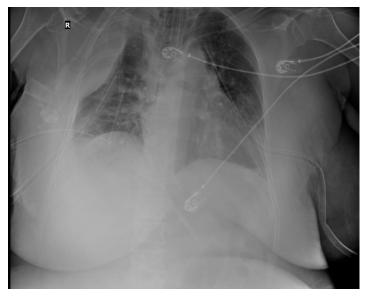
The patient's chest X-ray showed pleural effusion, bilateral consolidation at the base of both lung and placement of two chest tubes on the right side of the chest.
